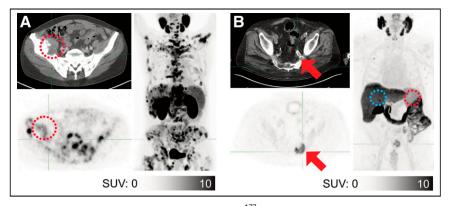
Exemplary cases of patients referred to ¹⁷⁷Lu-PSMA therapy. PSMA-11 PET imaging showed destructive osseous metastasis with large PSMA-negative soft-tissue component (A, dashed red circle). Therefore, patient was rated as not eligible for ¹⁷⁷Lu-PSMA therapy by PSMA PET-only VISION analysis. PSMA-1007 PET imaging demonstrates bone metastasis (B, arrow) with uptake lower than liver (B, blue dashed circle), and thus VISION analysis excluded the patient from ¹⁷⁷Lu-PSMA therapy. In the modified VISION analysis using spleen instead of liver as threshold organ, the patient was included as bone metastasis had higher uptake than spleen (B, red dashed circle).
